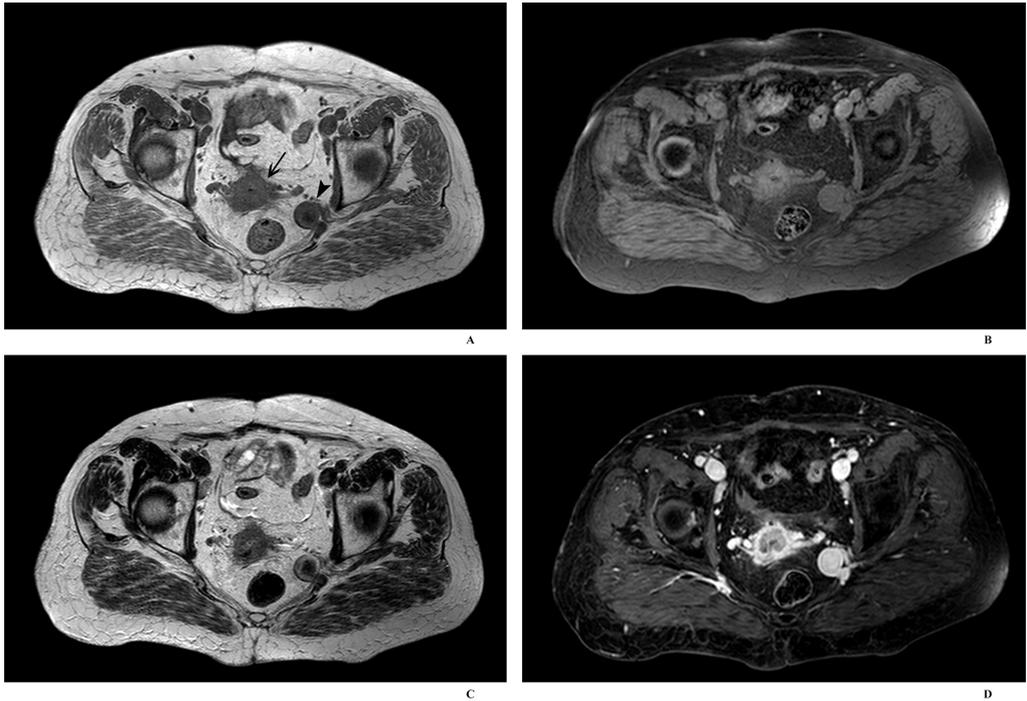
The saccular aneurysm of the terminal part of the left internal iliac artery (arrow head) and cervical cancer (arrow) on axial sections. A — T1-weighted image, B — WAVE image, C — T2-weighted image, D — T1-weighted image with fat saturation and contrast enhancement (late phase).
